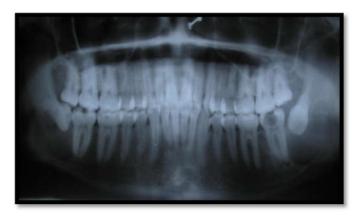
Orthopantomogram showing bilateral radiolucency inrto impacted 38 and 48 teeth.
